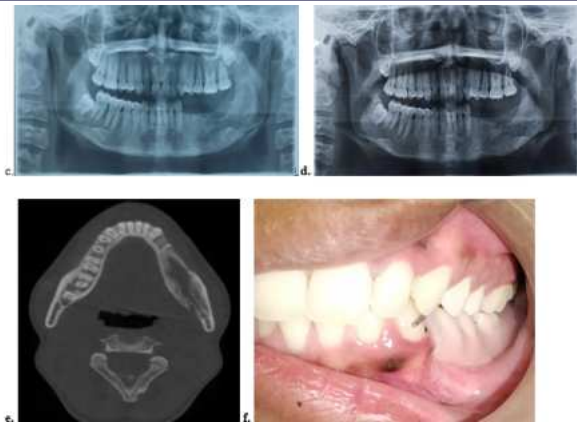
Post operative photographs: (a) 6 weeks postoperative Orthopantomogram;(b) 3 months postoperative Orthopantomogram; (c) 6 months postoperative Orthopantomogram; (d) 8 months postoperative Orthopantomogram; (e) 10 months postoperative Cone Beam Computed Tomography; (f) Prosthetic rehabilitation
